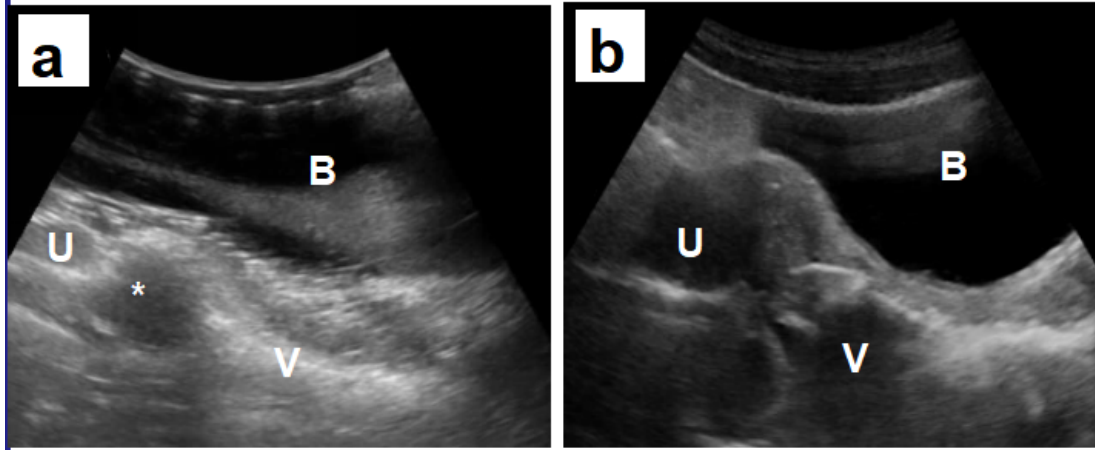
Ultrasound images of the pelvic anatomy. (left) 3rd prototype under ultrasound. (right) actual patient ultrasound. Note the similarities in structure between the two. Structures included in both are bladder (B), uterus (U), vagina (V). Tumor indicated by asterisk (*).
